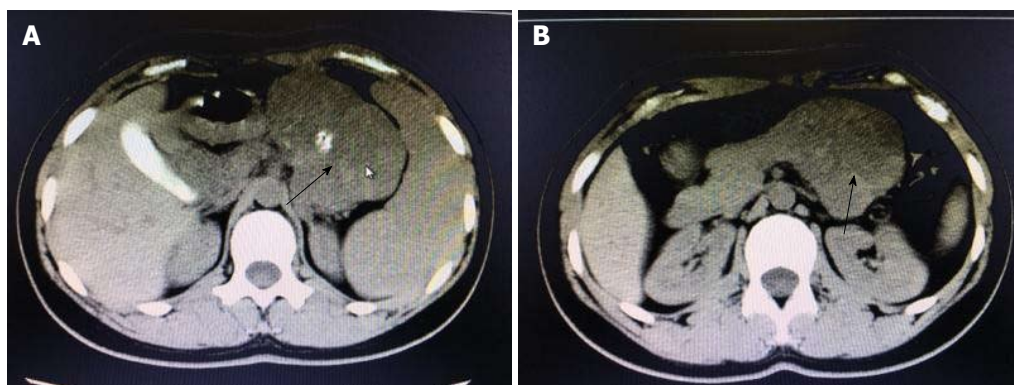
Findings of plain abdominal computed tomography scan. A: Plain abdominal computed tomography reveals a soft-tissue mass in the body and tail of pancreas; B: It has a well-defined border and sized 8.5 cm × 6.1 cm × 6.5 cm, with heterogeneous signal intensity patches and nodular calcifications. It is closely associated with gastric wall. Arrow indicates the mass.
